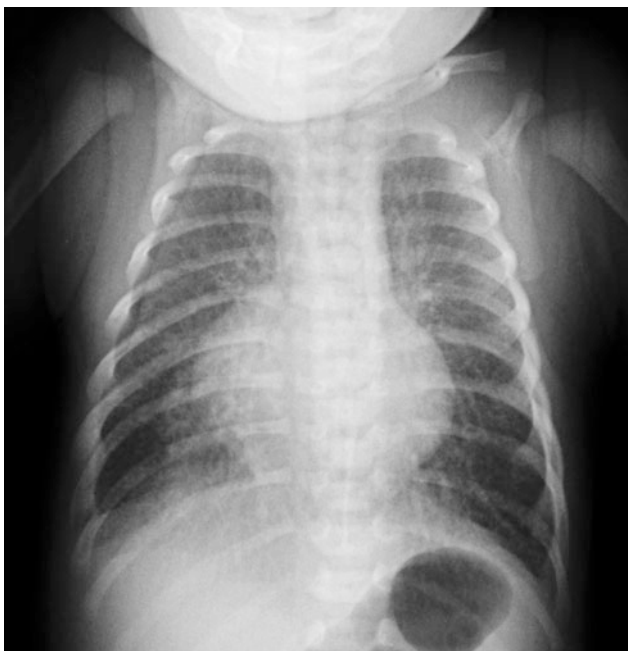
Frontal chest radiograph obtained in supine showing increase in density of the left hemithorax caused by pleural fluid layered under the lung
